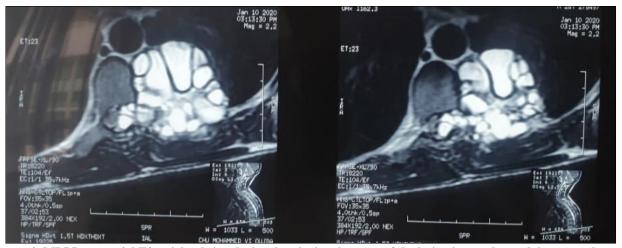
MRI Image axial T2 weighted signal: showing the involvement of the lesion into endocanalaire space through the foramen
